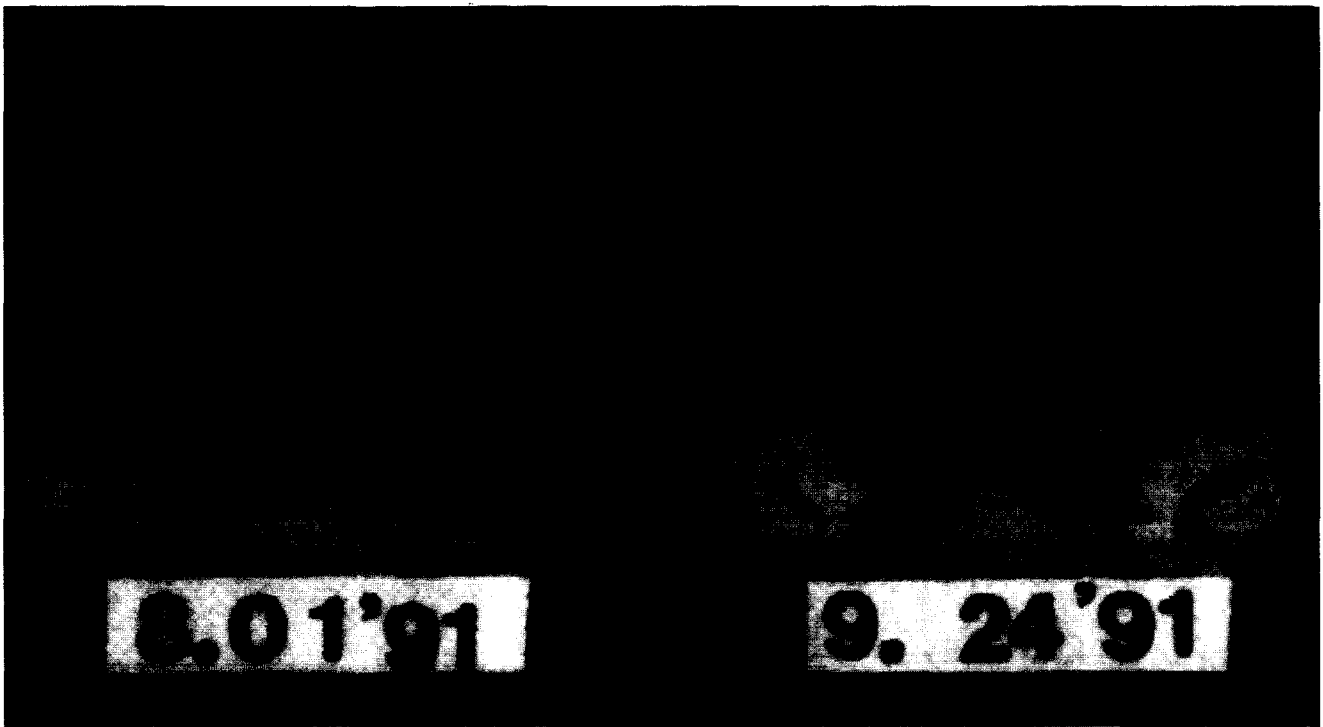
CT (computerized tomographic) scan of upper nasal cavity before and after half body irradiation (HBI). Nasal tumor, through completely outside HBI field, completely disappeared after low-dose HBI.
